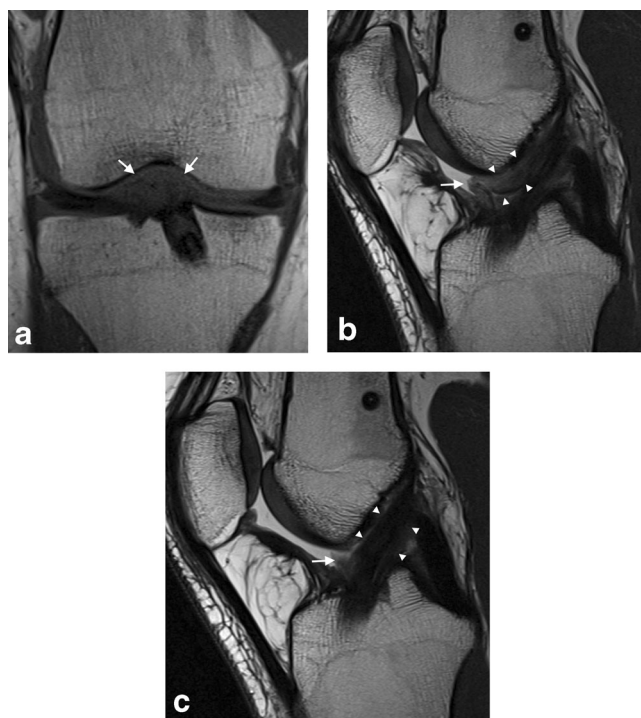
A 20-year-old female with previous ACL reconstruction using a hamstring tendon autograft. a Coronal T1-weighted MR image (TR 650, TE 11) demonstrates an intermediate signal intensity nodule, i.e., “pseudocyclops” (arrow), in the anterior intercondylar notch. b Sagittal intermediate-weighted MR image (TR 5,100, TE 50) demonstrates the intermediate signal intensity nodule, “pseudocyclops” (arrow), in the anterior intercondylar notch with the displaced fibers from the graft extending directly from the femoral tunnel (arrowheads), differentiating the finding from a cyclops lesion. c Intermediate-weighted MR image (TR 4,690, TE 50) from 1 year later demonstrates an intact graft (arrowheads) and debrided torn ACL graft fibers (arrow)
